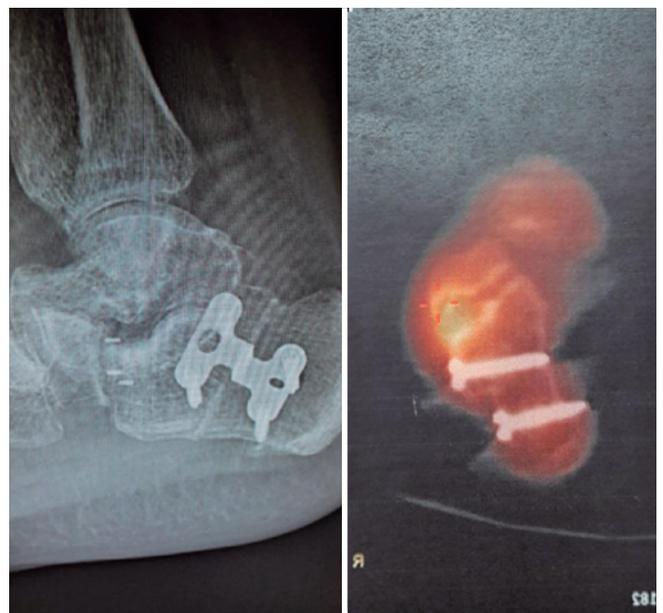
Left: image showing tuberosity after Evans osteotomy. Right: SPECT CT scan with hypercaptation at the calcaneocuboid joint.
